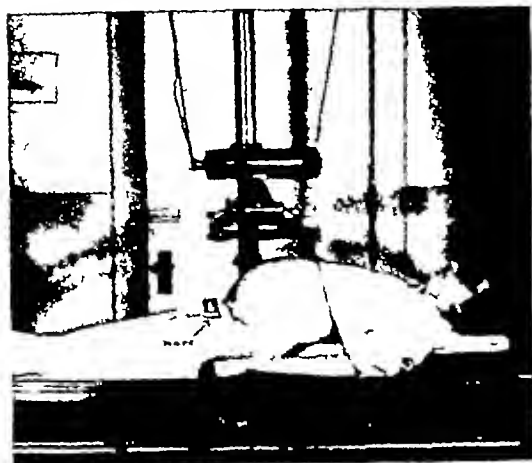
Patient in position for roentgenography of pelvis for the Moloy stereoscopic study. Note the 9 centimeter markers placed just below the symphysis pubis.
